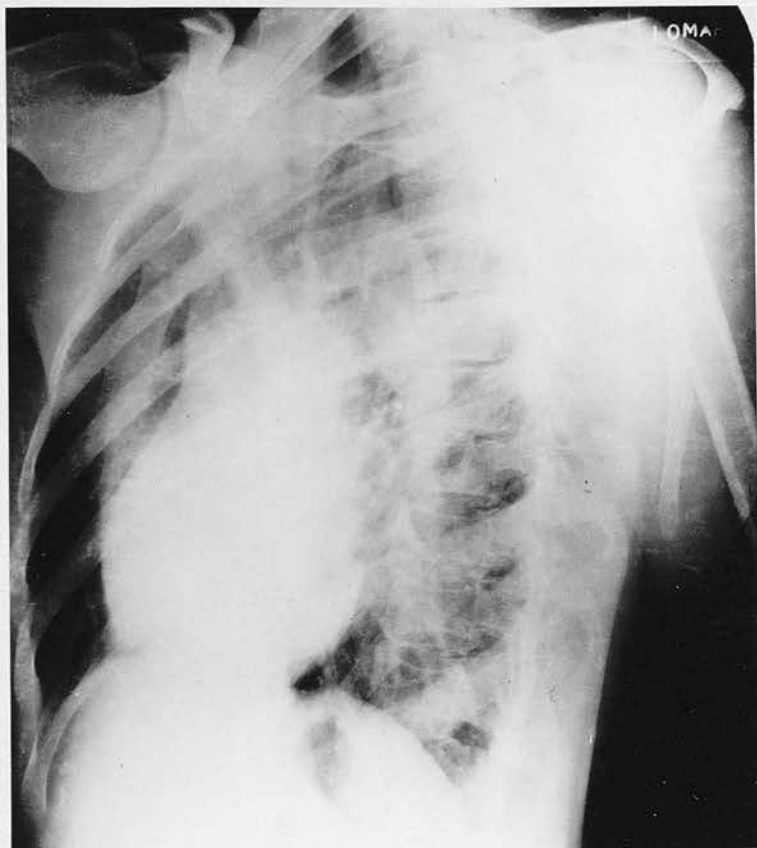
Radiograph of Case 70. Patent Ductus
